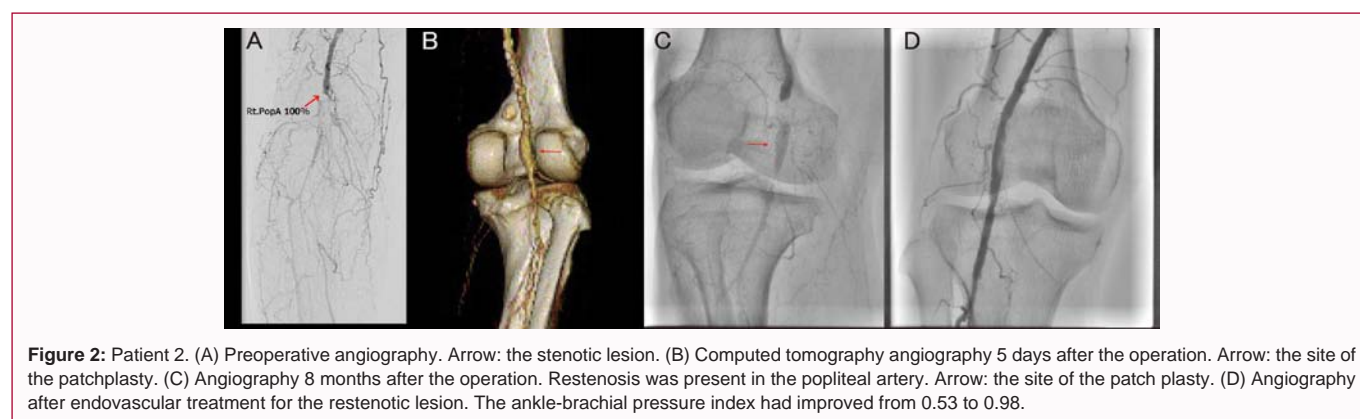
Patient 2. (A) Preoperative angiography. Arrow: the stenotic lesion. (B) Computed tomography angiography 5 days after the operation. Arrow: the site of the patchplasty. (C) Angiography 8 months after the operation. Restenosis was present in the popliteal artery. Arrow: the site of the patch plasty. (D) Angiography after endovascular treatment for the restenotic lesion. The ankle-brachial pressure index had improved from 0.53 to 0.98.
